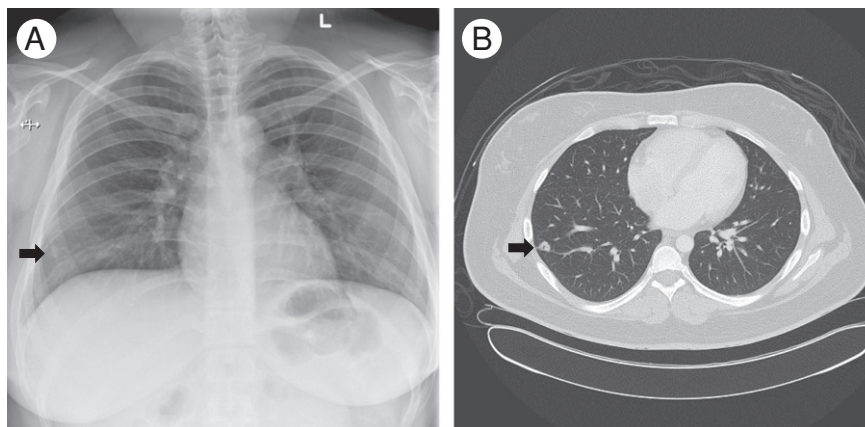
A, Chest x-ray showing nodular opacity (black arrow) in right lower zone. B, Computed tomography of the thorax showing well-defined 1.2-cm nodule (black arrow) in the laterobasal segment of the right lower lobe with eccentric lucent area suspicious for an area of cavitation.
